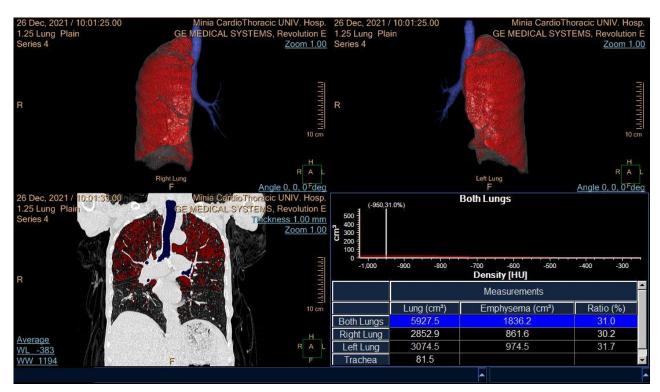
the case is for male patient 70 years old, ex smoker for 10 years, volumetric CT shows emphysematous changes on both lung fields about 31%, more affecting both upper lung lobes.
